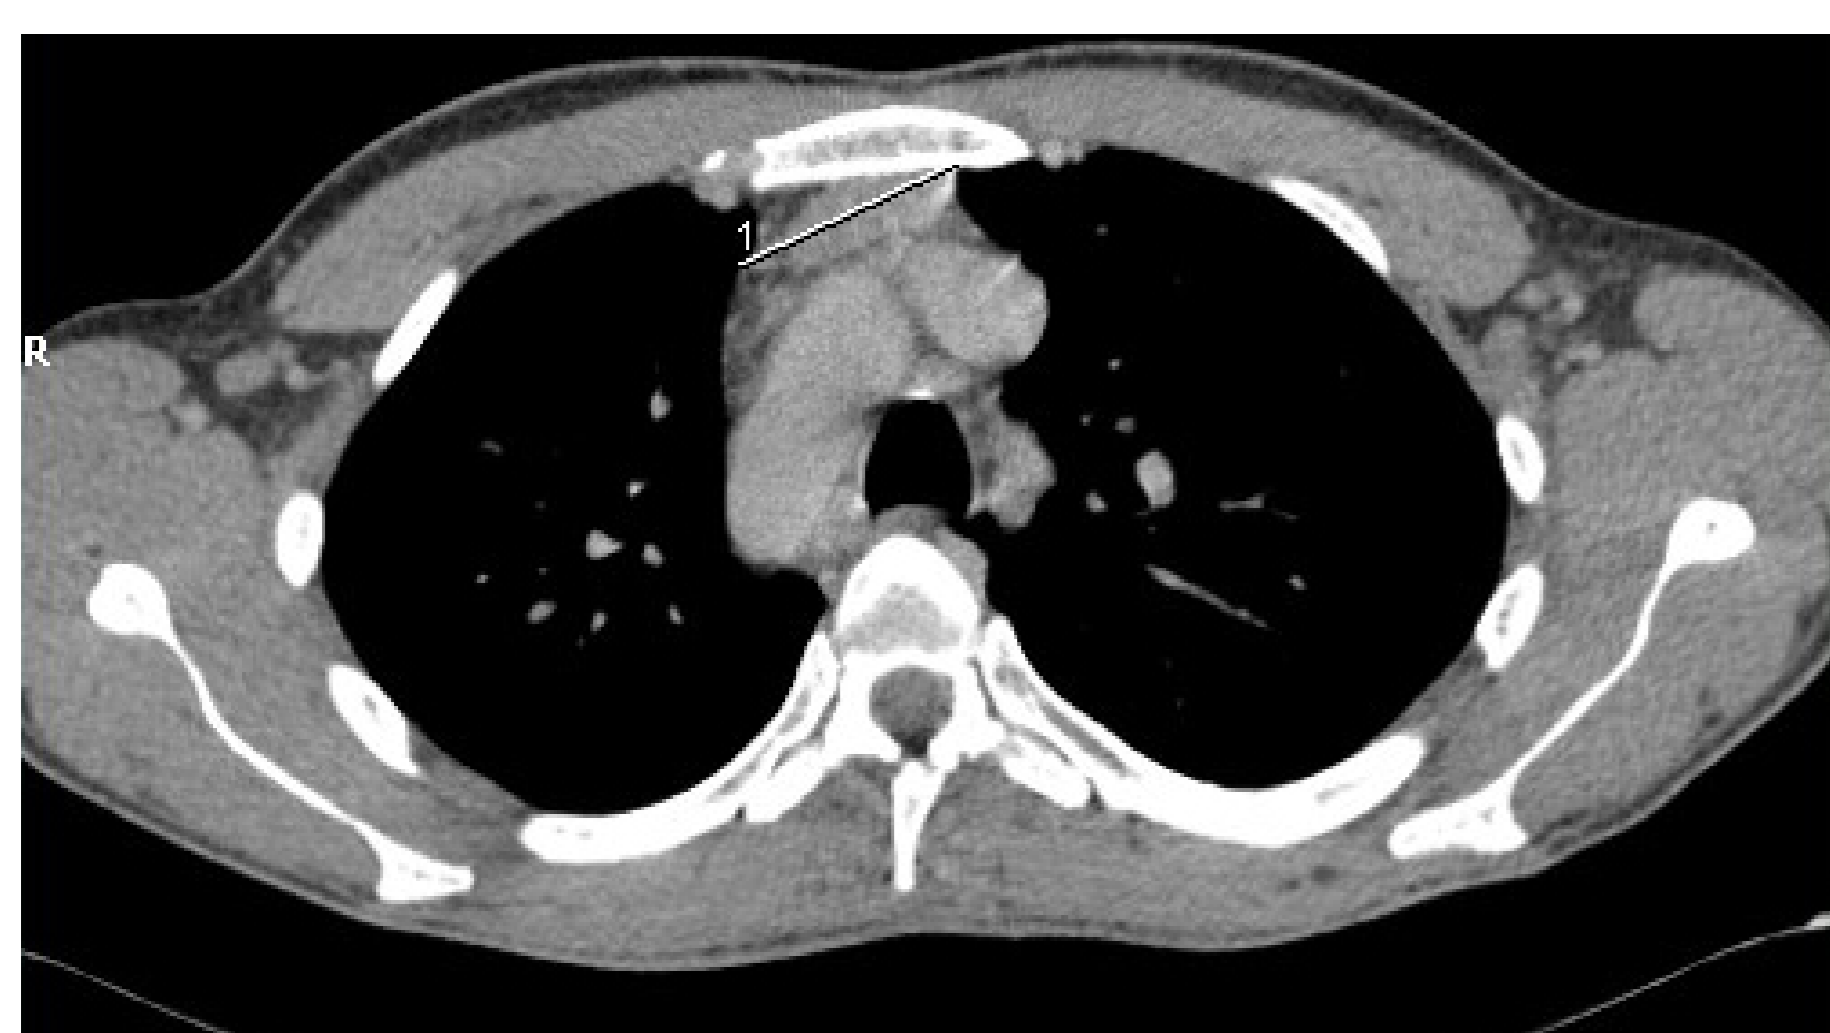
CT image of well-contoured, homogenous thymus mass at the time of the diagnosis, interpreted as hyperplasia; CT was made for persistent cough.
